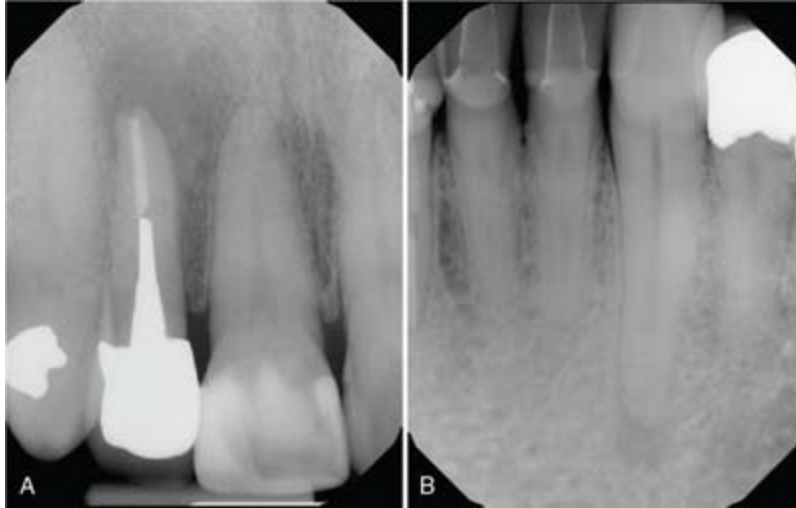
A, Biopsy revealed a periapical cyst at the apex of tooth #7. There is a loss of trabeculation at the apex blending into normal bone resulting in an ill-defined radiolucency. B, Well-defined periapical granuloma at the root apex of tooth #27 was confirmed with a biopsy when bone loss and symptoms persisted following nonsurgical root canal treatment. Size and radiographic definition of periapical cysts and periapical granulomas are highly variable.
